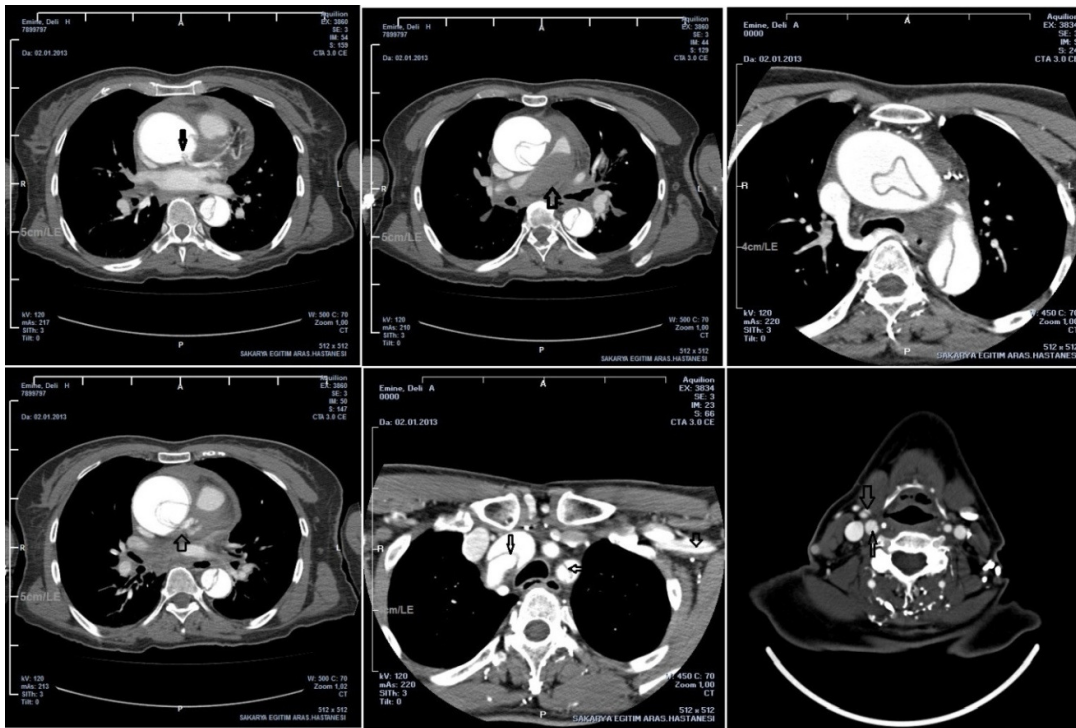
Urgent carotid and thoracoabdominal contrast CT angiography revealed an extensive Stanford type A aortic involving the aortic root, ascending, arch, descending segments of the aorta, with involvement of the left subclavian-axillary, carotid and brachiocephalic arteries, and ascending aneurysm, aortic rupture leading to hemopericardium, hemomediastinum compressing pulmonary arteries
